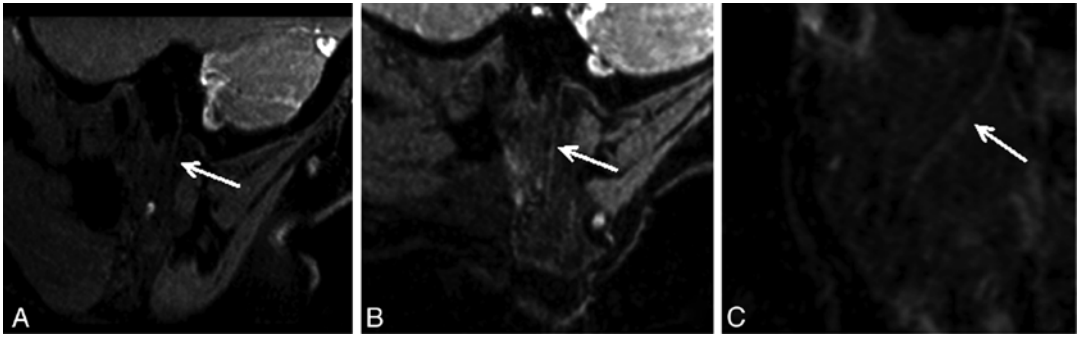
3D-PSIF-DWI (a) Oblique sagittal MPR image shows the main trunk of the intraparotid facial nerve as a linear structure of high-signal intensity compared with the parotid gland (*arrow*). (b) Oblique sagittal MIP image shows the main trunk of the intraparotid facial nerve and cervicofacial division. (c) Oblique coronal MIP view also displays the main trunk of the intra-parotid facial nerve
